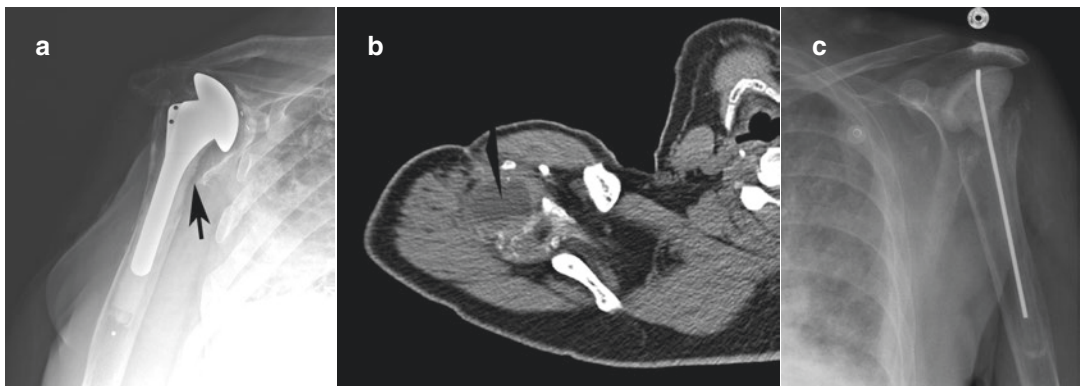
Infection. (a) Grashey image of a right total shoulder arthroplasty shows focal erosive change along the proximal humerus (arrow), concerning for infection. (b) CT axial image of the right shoulder demonstrates a large soft tissue mass. (c) AP image post-explanation of a left total shoulder arthroplasty shows antibiotic-impregnated cement spacer and pin
